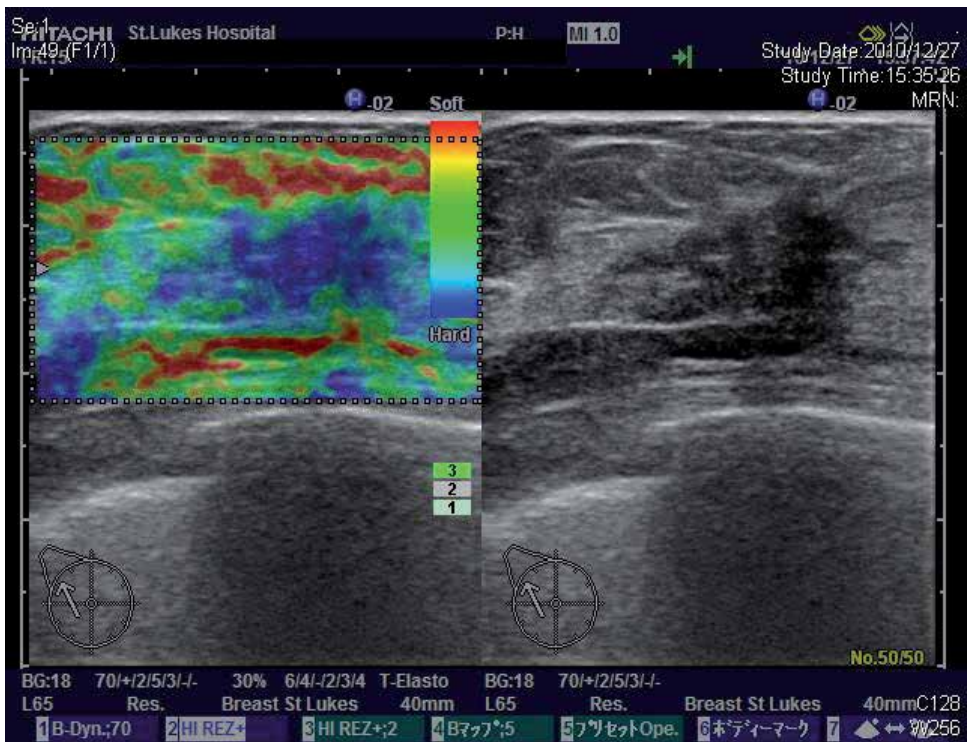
A second representative case of DCIS, Ultrasound; elastography (above) and collar Doppler view (below).
